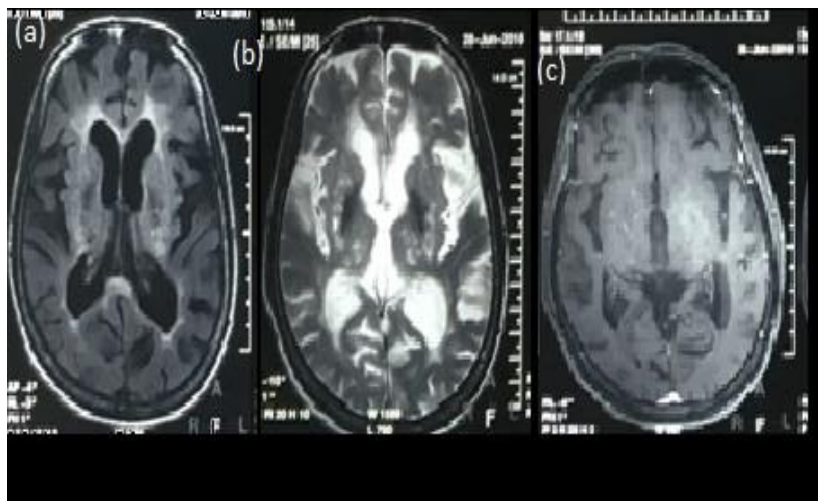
CMV Encephalitis: Axial T2/FLAIR images show hyperintense signal in bilateral fronto-parietal lobe and basal ganglia (a,b), contrast enhancement in both fronto-parietal lobes on post contrast image (c).
